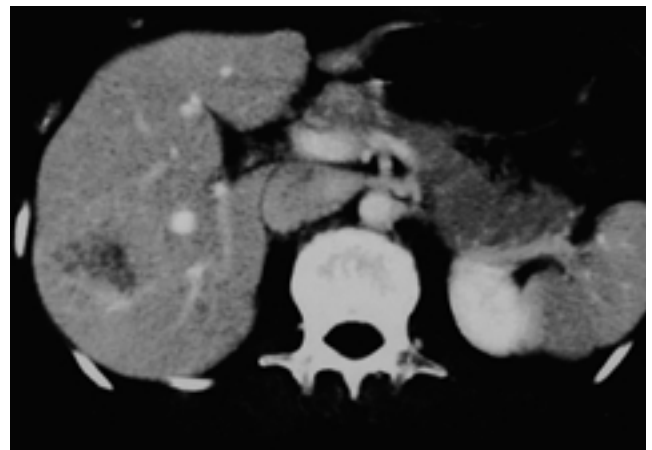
The portal phase of 3-year follow-up CT shows no significant interval change of lesion.
